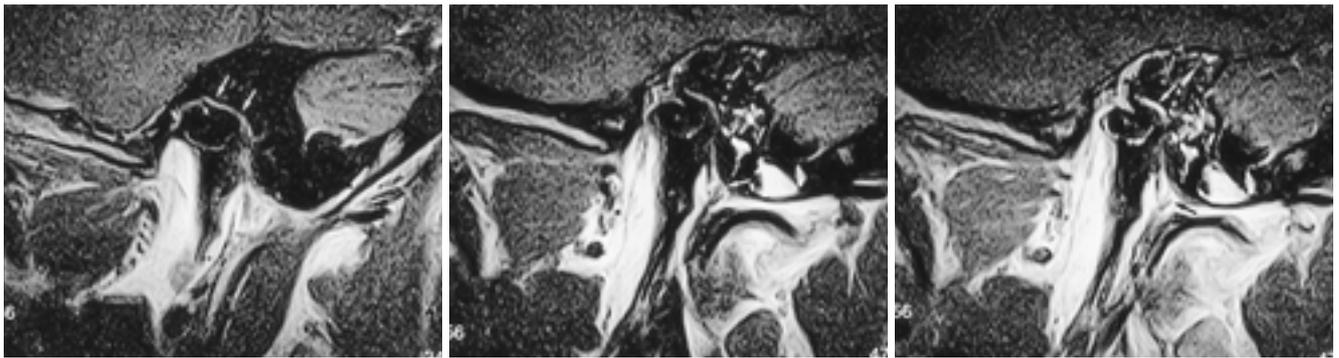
37-year-old man with posttraumatic Rt. facial palsy resulting from ipsilateral temporal bone fracture. MR images were obtained 2 weeks after onset of symptoms.
